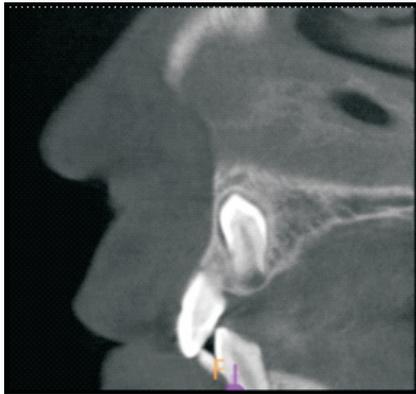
CBCT showing inverted tooth budirt 22
